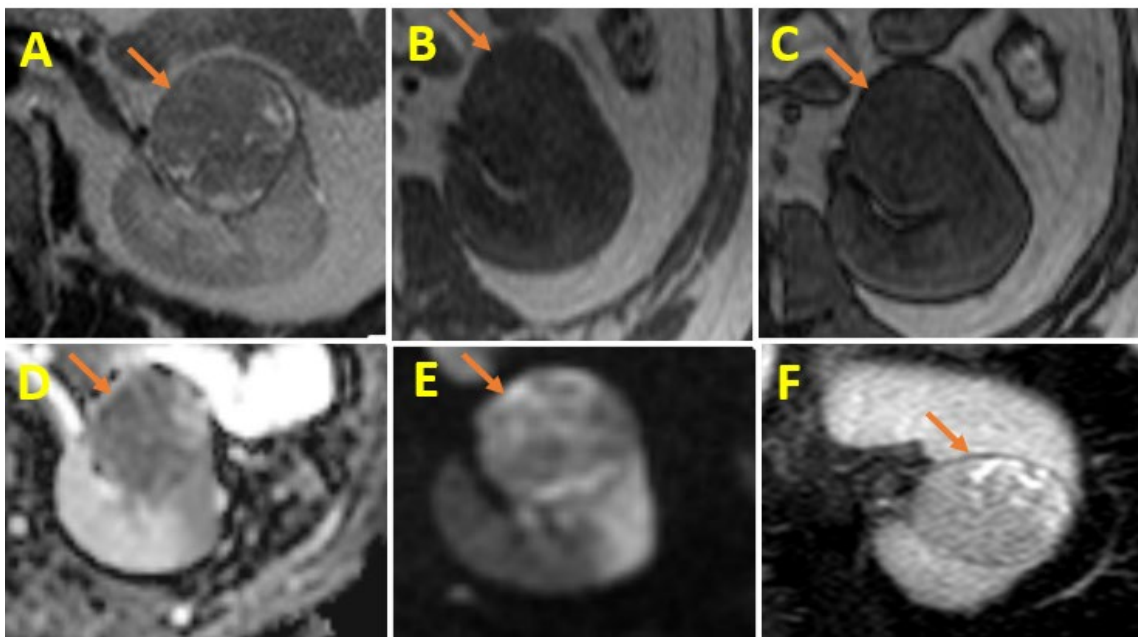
Selected sections of non-contrast MRI of the upper abdomen (A) axial T2WI, (B) axial T1WI, (C) T1WI with fat saturation, (D) DWI, (E) ADC map, (F) coronal T2 STIR: show well-defined solid mass involving/exophytic from the anterior aspect of the interpolar region of the left kidney (orange arrows), iso intense in T1WI, not suppressed in fat sat sequence, heterogenous iso/hypo intense SI in T2WI, restricted in DWI and ADC map.
